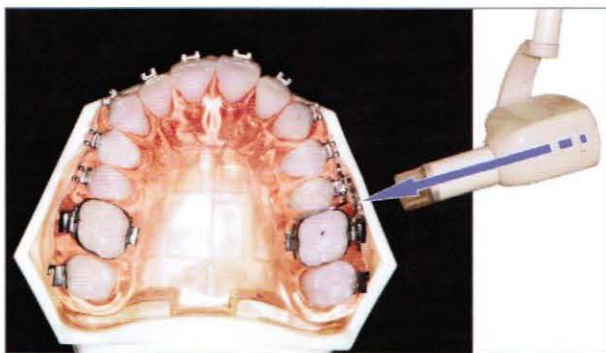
The most important factor during x-ray taking
